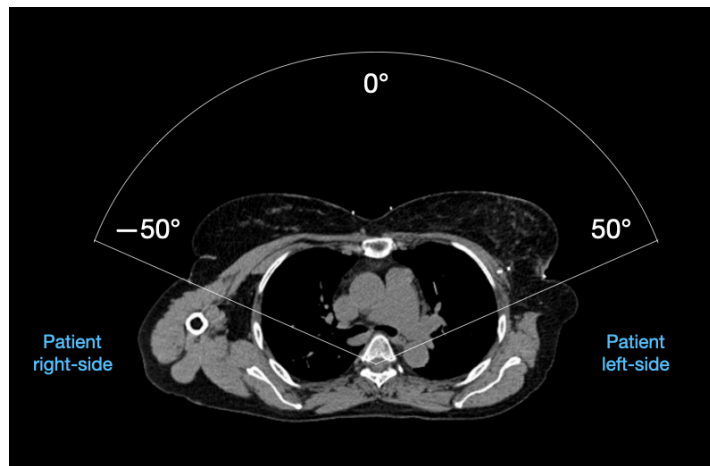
Axial plane of a CT scan of a torso with visualized beam directions. For left-sided breast cancer, the beam angle range is between 0° and 50° and for right-sided, the beam angle range is between 0° and -50° .
